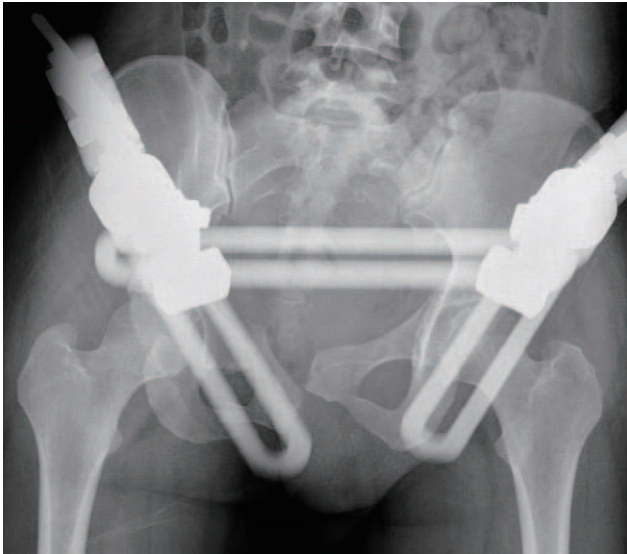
Anteroposterior pelvis X-ray of patient just after fixation of the pelvis with external fixator. Although the symphysis pubis diastasis is reduced, the pubic bone looks displaced.
